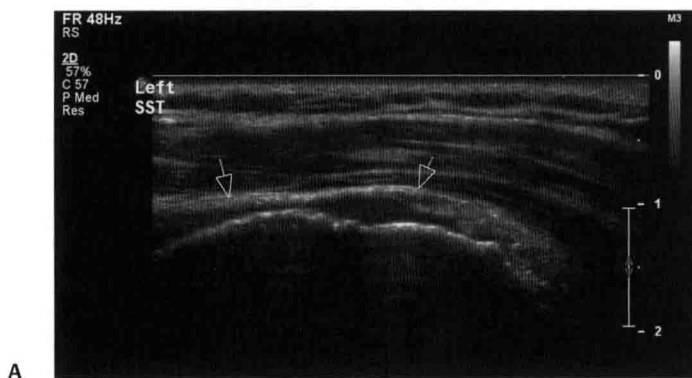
Supraspinatus tendon large full-thickness tear. (A) Transverse ultrasound view. The tendon is not seen and a thin layer of fluid fills the gap between the subdeltoid bursa (arrows) and the humeral head. (B) Coronal T1-weighted fast spin echo (FSE) and (C) coronal proton density (PD) FSE fat-suppressed (FS) magnetic resonance images demonstrate a complete tear and retraction of the supraspinatus tendon (arrow). Supraspinatus fat replacement due to muscle atrophy and upper subluxation of the humeral head are secondary findings.
